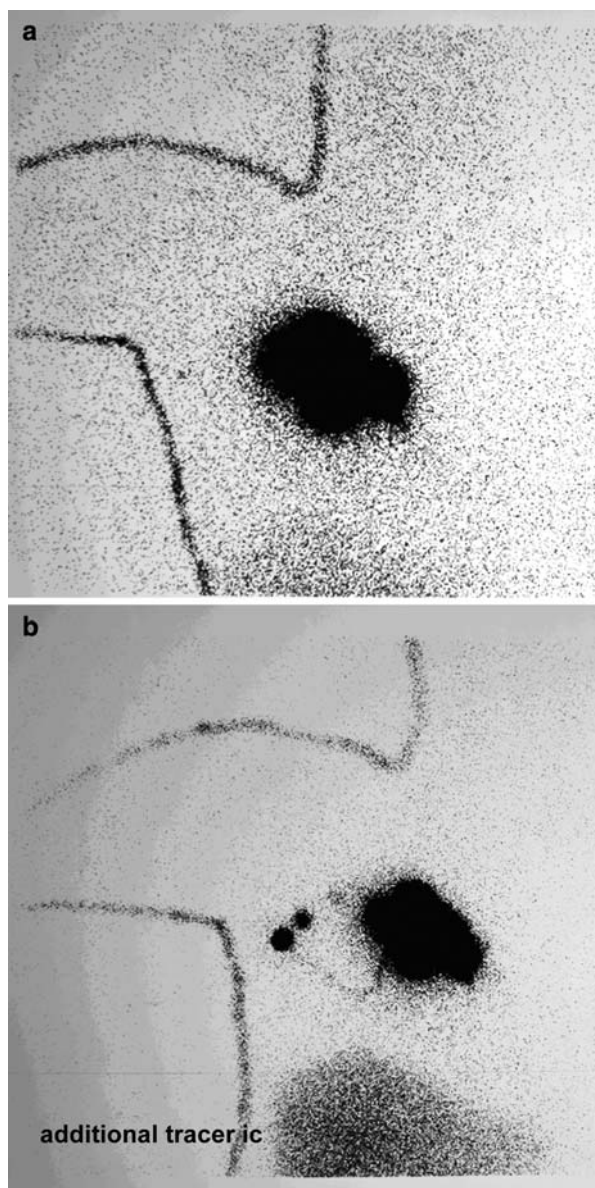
Lymphoscintigraphy of patient with initial scan failure (a), but secondary SN visualization after additional tracer injection (b)
